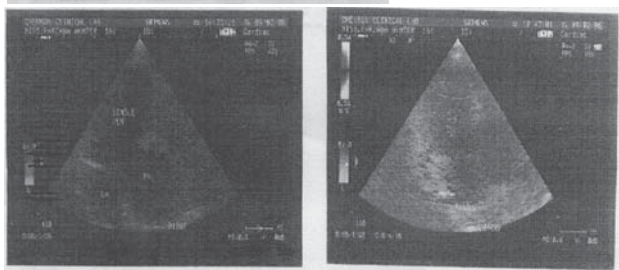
Echocardiography in 2D: M-Mode and Colour Doppler Study
